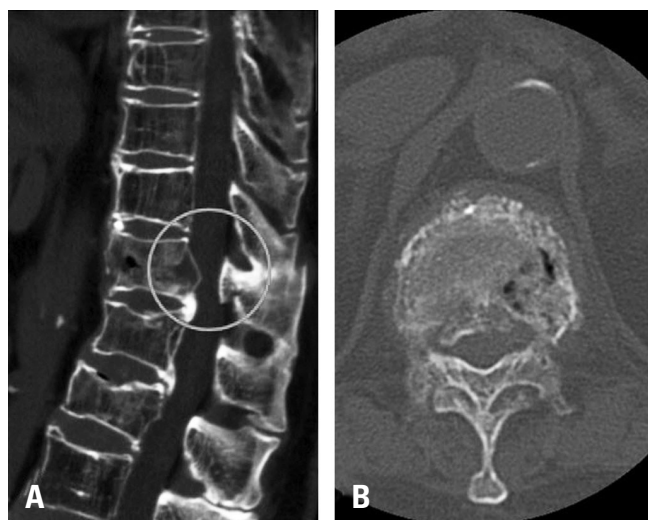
Progression of the canal-compromising lesion on follow-up (A) sagittal and (B) axial computed tomography images.
